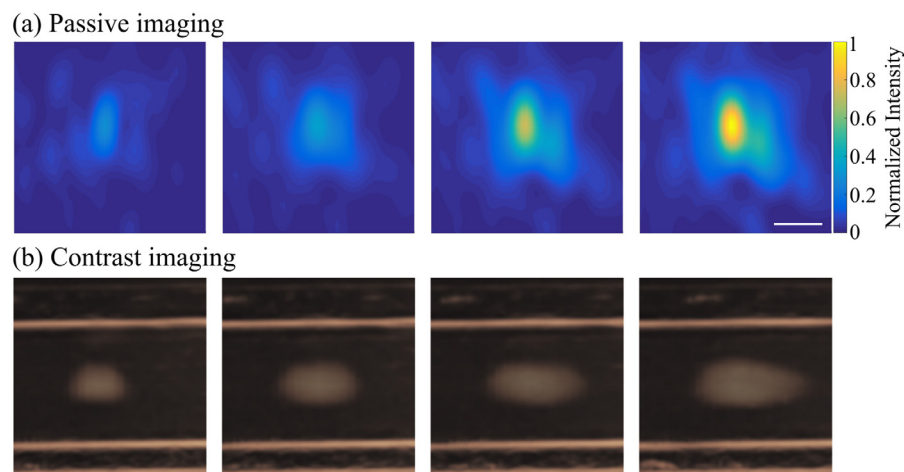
Cloud growth over sequential sites of sonication as observed in passive imaging (row (a)) and contrast imaging (row (b)). Each column corresponds to data from a different site conveyed as a sum projection over time. Passive images were additionally subject to sum projections along the x -direction (into the page) spanning 1.5 mm about the center of the vessel for a more direct comparison with the ~ 1.5 mm ultrasound imaging slice thickness. Data from short duration exposure sites, each separated by 1 mm (scale bar is 25 mm).
